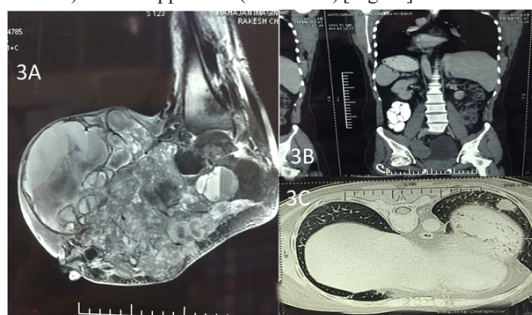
(3A-MRI Foot showing large multi lobulated, mostly solid with component of heterogeneous enhancement and increased vascularity and at places cystic areas with fluid levels suggestive of hemorrhages. Complete loss of tarsals and metatarsals. Posterior part of calcaneus and phalanges visualized); (3B-CECT abdomen showing metastasis in supra splenic area, small lymph nodes in para-aortic and retrocaval location); (3C-lung metastasis in left lower lobe)
